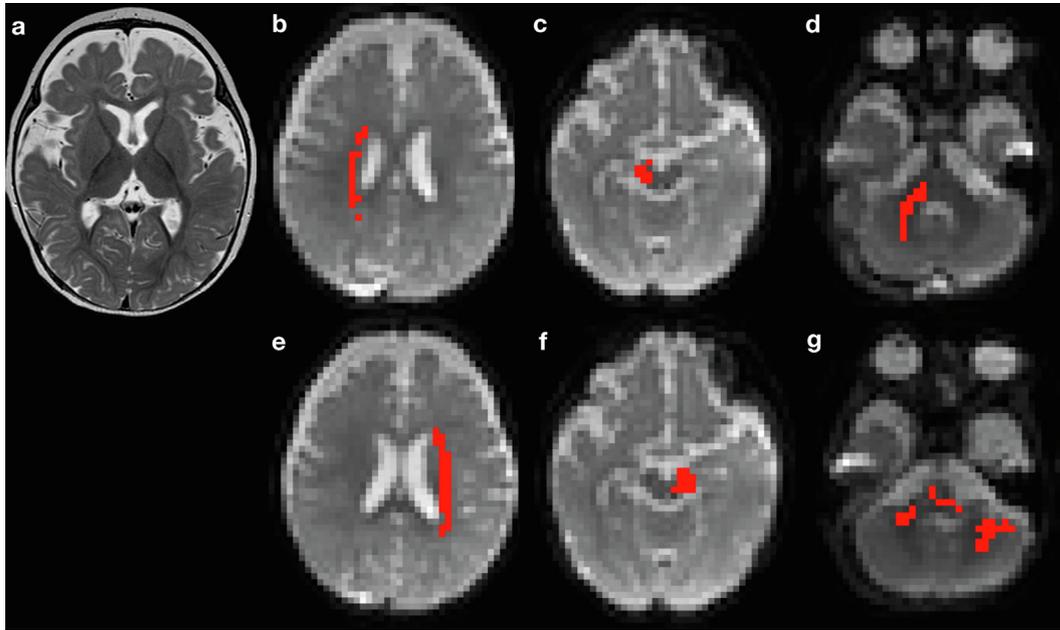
An 8-month-old patient with MRI-negative West syndrome of unknown etiology; mixed pattern. a: T2-weighted image shows mild brain atrophy after ACTH therapy. b–d: Tractography shows an ipsilateral cerebellar distribution of CPC tracts when the ROI is placed in the right cerebral peduncle. e–g: Tractography shows bilateral cerebellar distributions of CPC tracts when the ROI is placed in the left cerebral peduncle.
